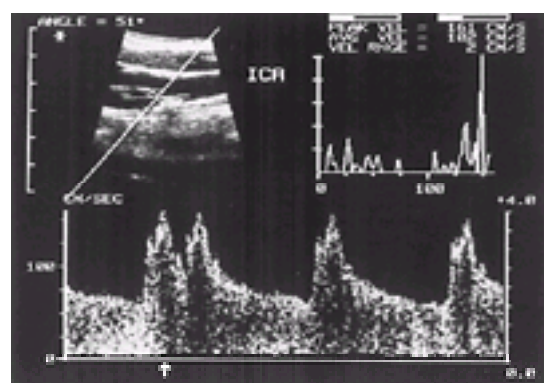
Spectrum of pulsed-Doppler signal obtained from an internal carotid artery with 50 to 79 per cent diameter stenosis. Peak systolic velocity is 161 cm/s and end-diastolic velocity is 65 cm/s. Plaque is visible on the wall of the internal carotid artery opposite the flow divider. The position of the sample volume and angle of interrogation are indicated. An optimum angle of 60° was not obtainable in this case.
